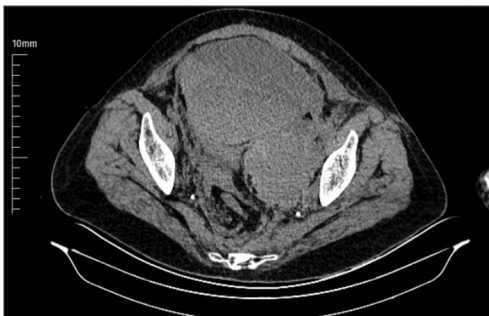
Hematoma, 19×13 cm in size, pushing the uterus and bladder to the right in abdominal computed tomography.
